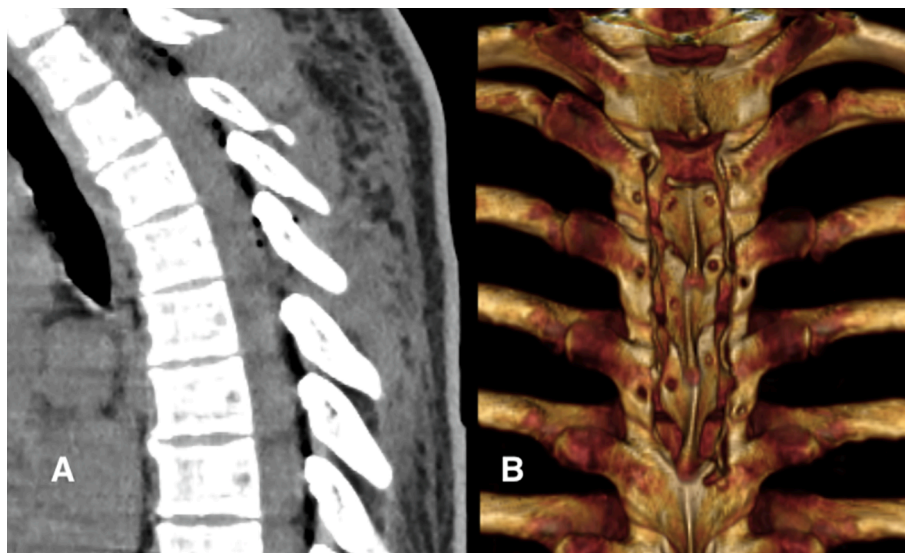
Patient 3 early postoperative images: (A) spinal CT scan shows the resection of the tumor without any complications; (B) the 3D reconstruction reveals the laminotomy's levels.
